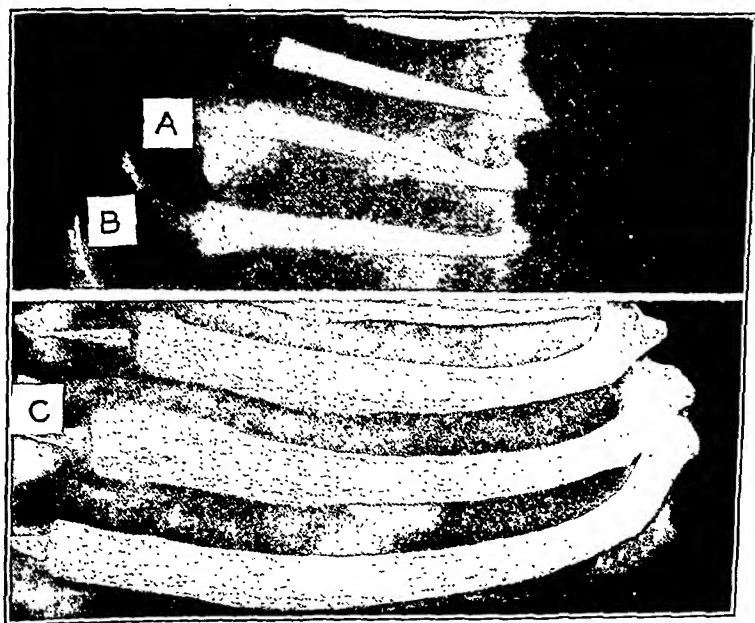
X-rays of ribs. A, Pup rib twenty-three days after elevated intramedullary pressure of 156 cm. for seventeen hours, followed by 1 c.c. of a culture of toxin-producing *Staphylococcus aureus*. Destruction of the rib at the tip with dislocation of the costochondral junction is seen. The destruction and new bone formation in the middle third of the rib is unusual, being limited usually to the tip. B, Pup rib twenty-nine days after elevated intramedullary pressure of 156 cm. of saline solution for ten hours. New bone is present about the tip of the rib. C, Adult rib thirteen days after the injection of 0.25 c.c. of toxin-producing staphylococcus culture into the rib. Destruction of areas of bone but little or no deposition of new bone has occurred.
